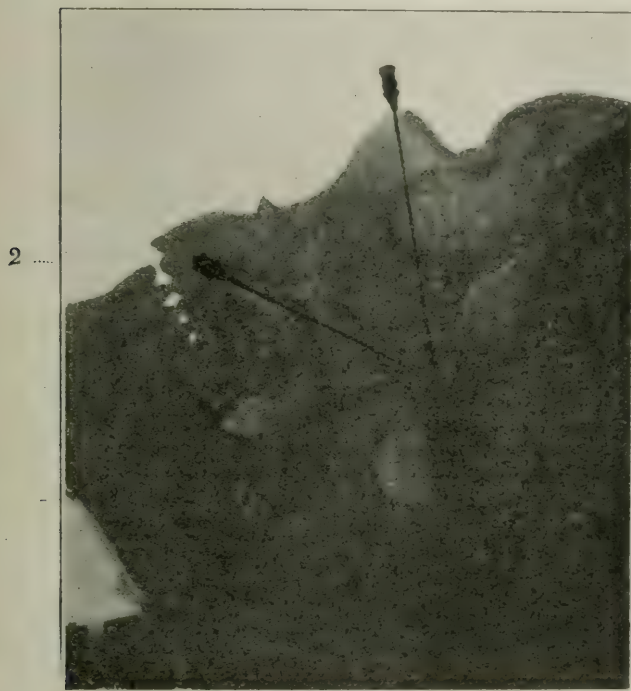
Radiograph of a patient showing the method of anesthesia of the superior maxillary nerve.
